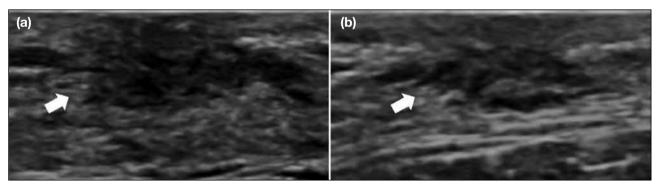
A 17-year-old male presented with a 3-month history of progressively enlarging bilateral chest wall masses. (a) Right breast. (b) Left breast. Ultrasound (US) showed triangular hypoechoic areas in the subareolar region of both breasts without increased vascularity on Doppler US (arrows), consistent with gynaecomastia.
